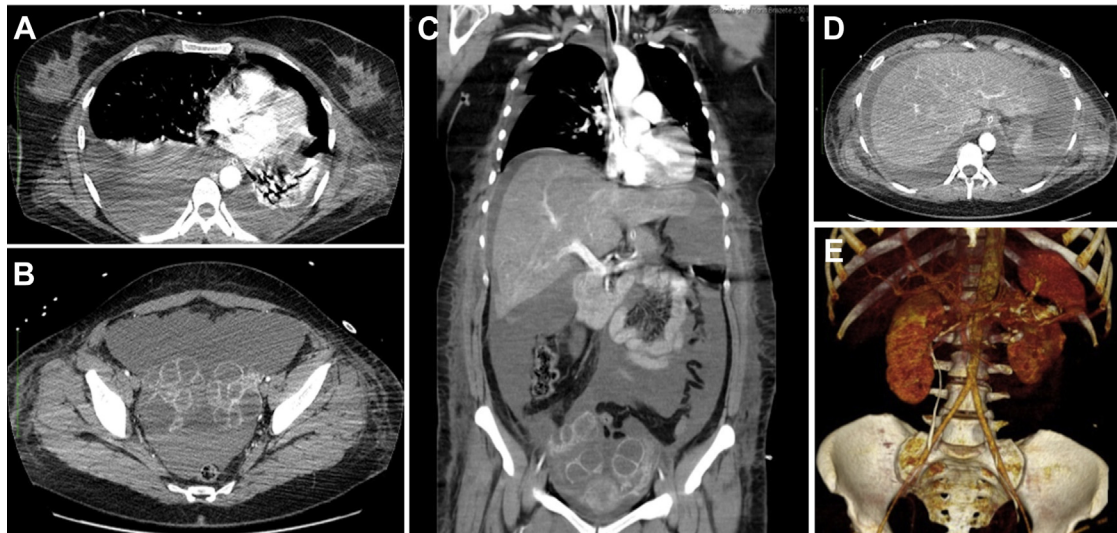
Computed tomography angiography in axial and coronal views showing bilateral pleural effusion (A), voluminous ascites (B-D), and increased ovarian volume (B and C). E, Three-dimensional volume rendering reconstruction with evidence of the segmental infarction in the lower pole of the left kidney.
